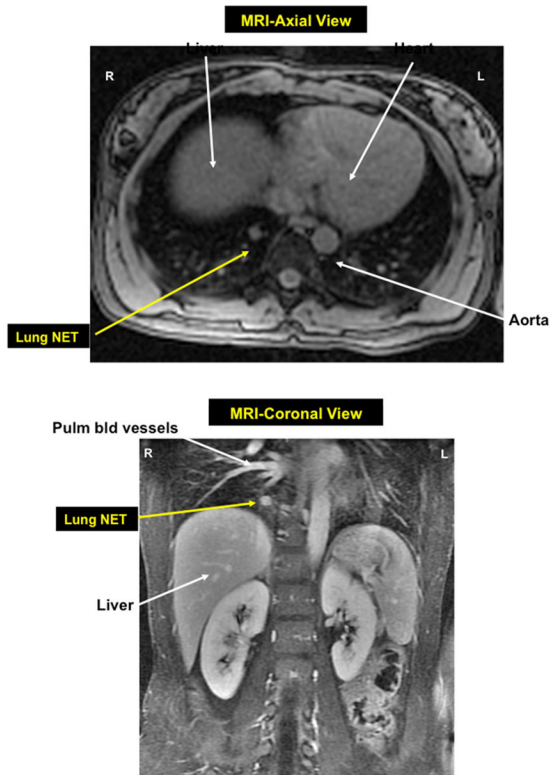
MRI axial view (top) and coronal view bottom of right lower lobe bronchial NET in patient with mEN-1
